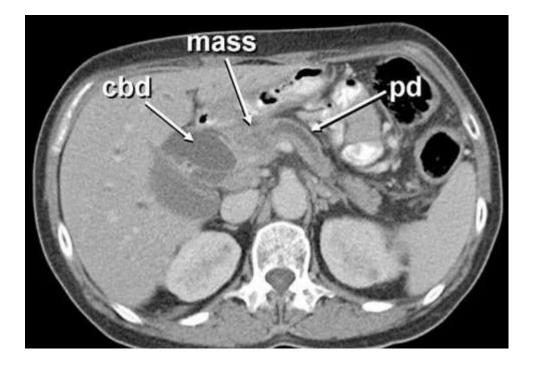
An abdominal CT scan shows a small hypodense, pancreatic mass causing obstruction of both the common bile duct (cbd) and pancreatic duct (pd). Source:https://images.medicinenet.com/images/slideshow/pancreatic_cancer_s6_mass.jpg
